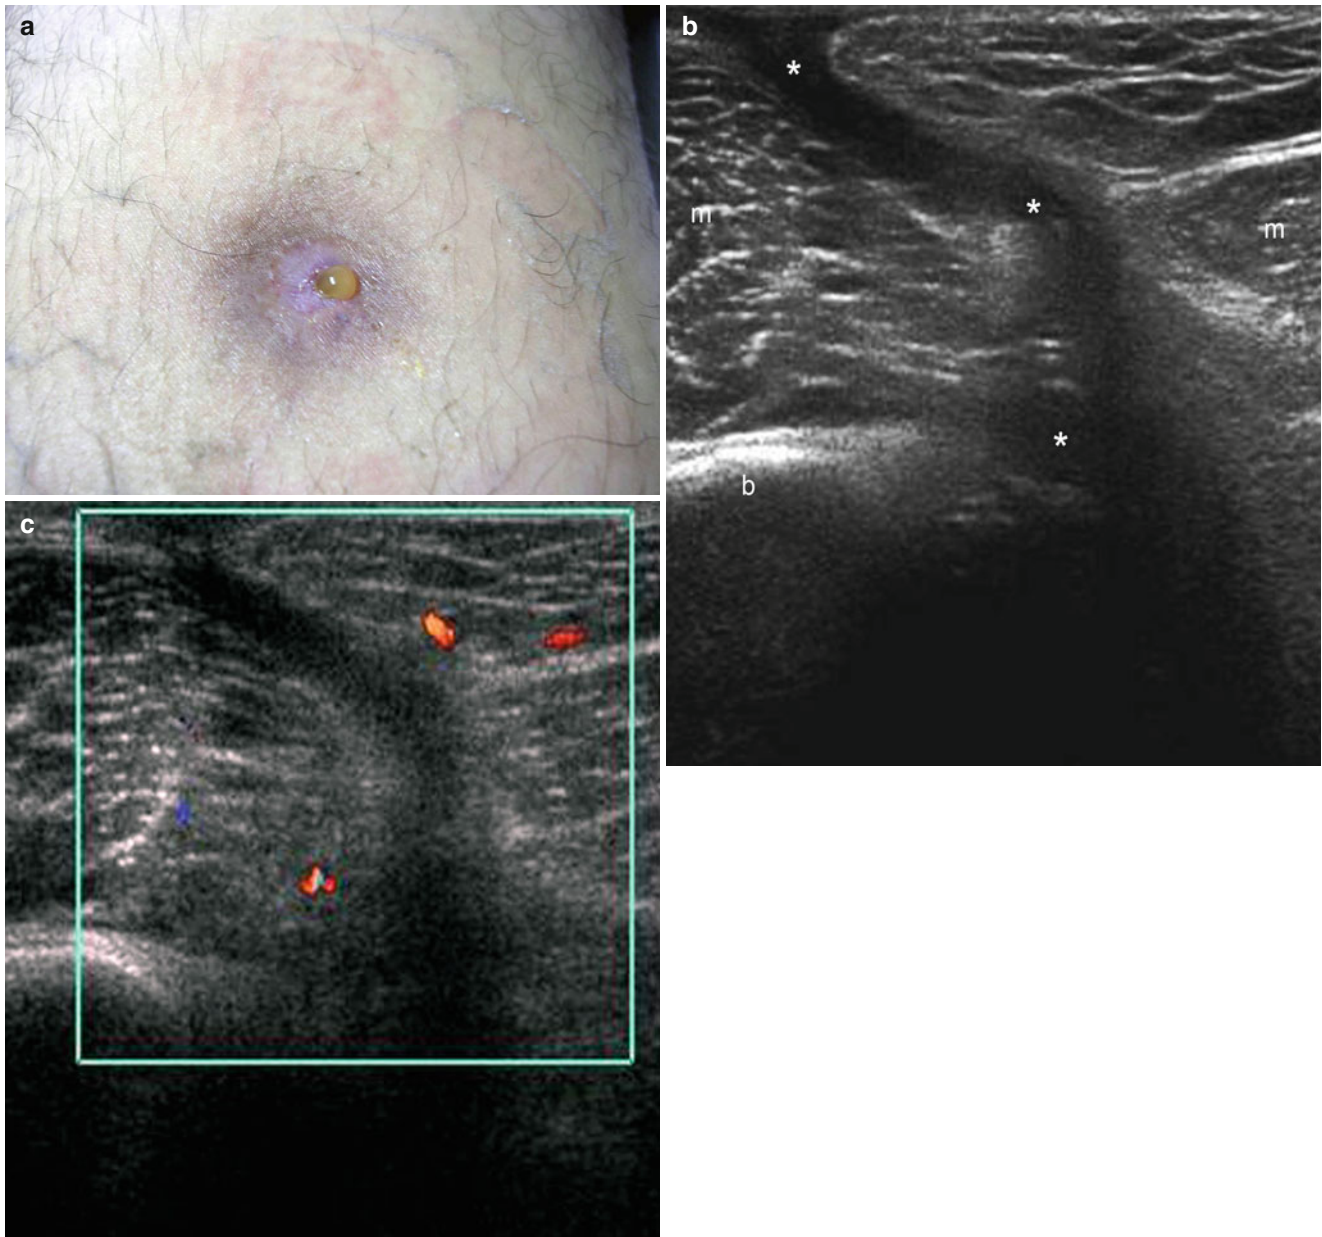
Fistula (osteomyelitis). (a) Clinical image shows an erythematous and pigmented macule that drains purulent material in the antero-medial aspect of the right thigh. (b) Grey scale ultrasound image (transverse view) demonstrates a hypochoic fistulous tract (*) that
